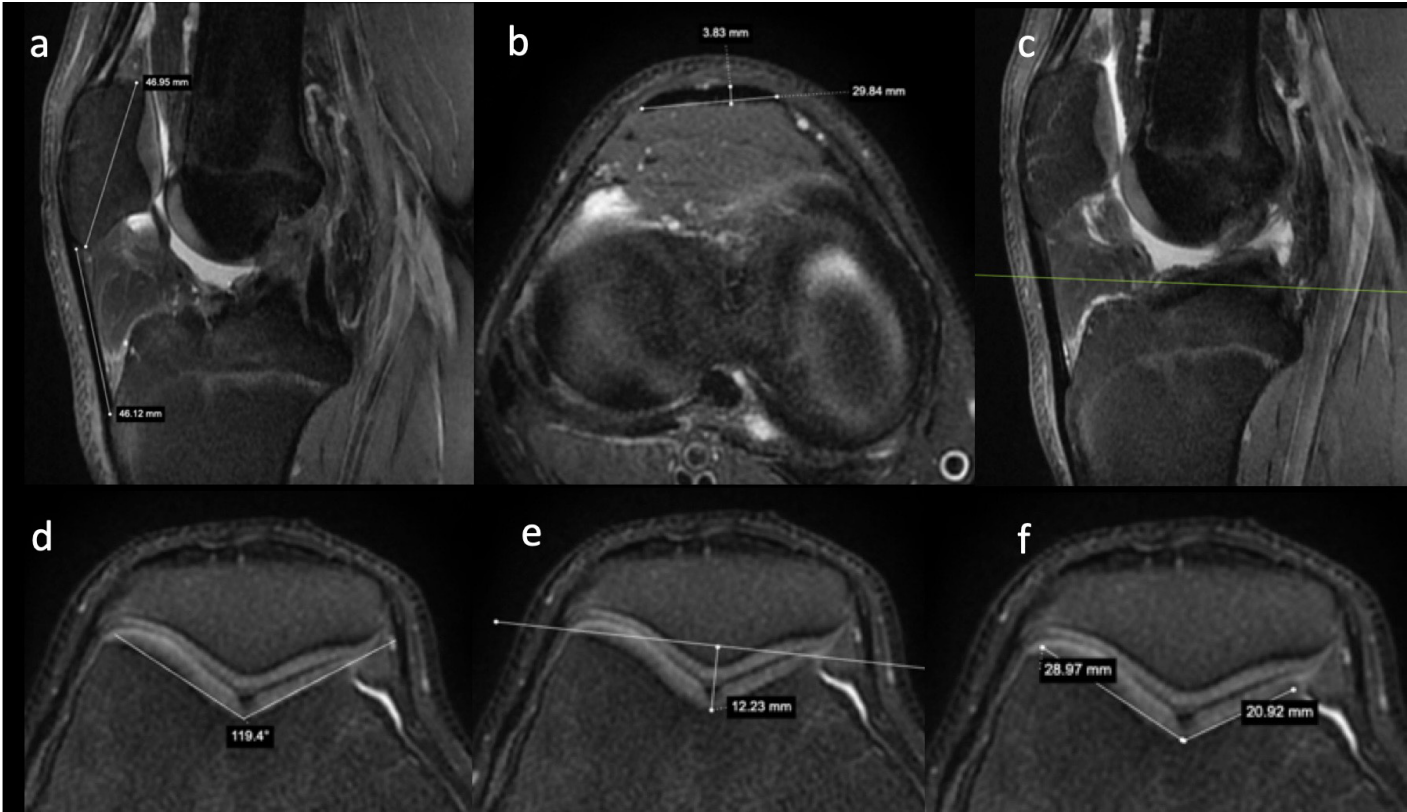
MRI-Based patellofemoral anatomical measurements; (a) Patellar tendon length and patellar bone craniocaudal length; (b, c) Patellar tendon anteroposterior thickness and mediolateral width; (d–f) Trochlear sulcus angle, trochlear height, and medial/lateral trochlear measurements
